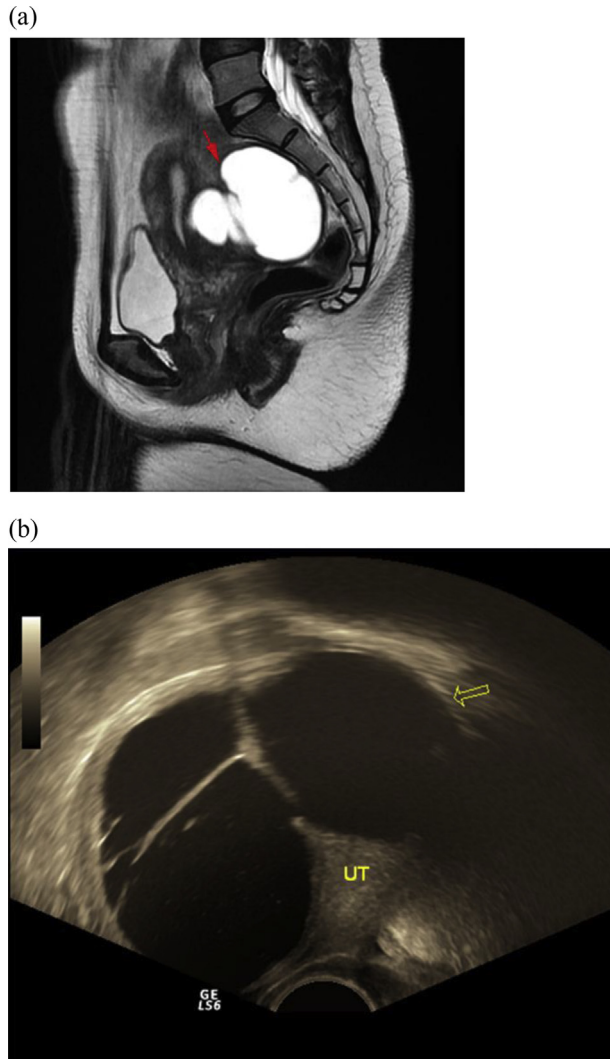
(a) Sagittal T2-weighted magnetic resonance imaging shows a $7.7 \times 6.4 \times 7.6$ -cm trilobular cyst (arrow) in the vesicouterine pouch. (b) Transvaginal sonography of the cyst in Fig. 1(a).
